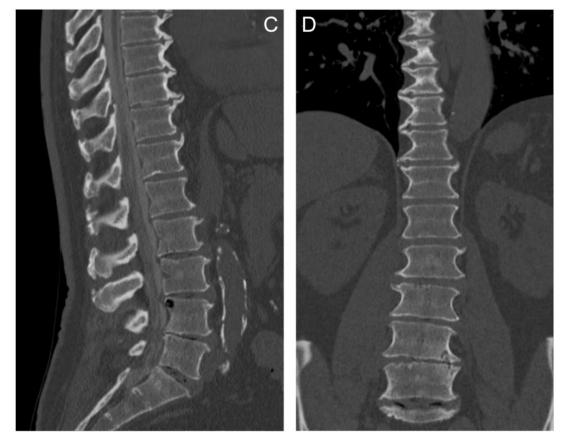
C: Sagittal CT-scan of the lumbar spine and D: Coronal CT-scan of the preop patient case profile. (Source: Klinikum rechts der Isar)
